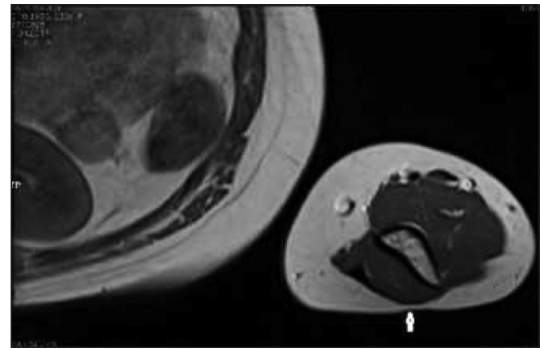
Axial non-contrast T1-weighted magnetic resonance image showing fat tissue thinning on the distal arm (white arrow).
